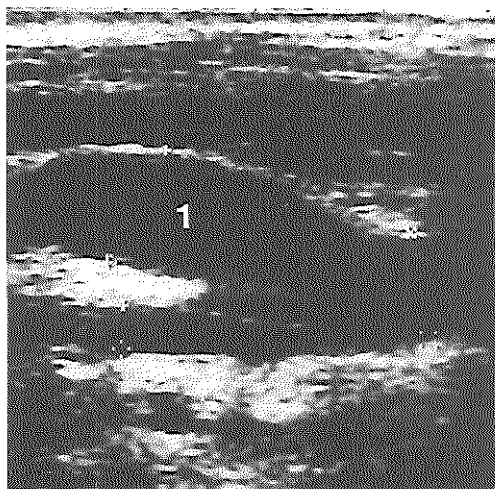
Longitudinal ultrasound view of the carotid artery bifurcation. The internal carotid artery shows an aneurysmal dilatation (1).
